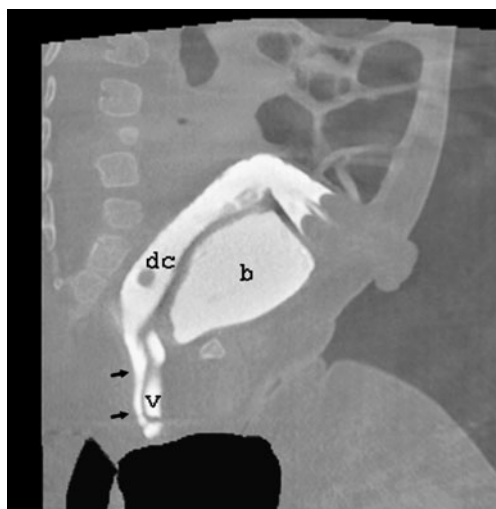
Sagittal CT-like image from a cloacagram nicely demonstrates the relationships among the sacrum, distal colon (*dc*), rectal fistula (arrows), vagina (*v*) and bladder (*b*)
